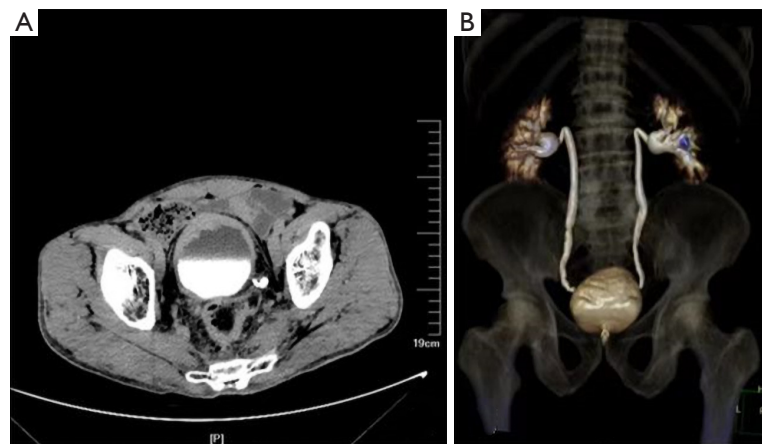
Imaging examination of the patient. (A) Computed tomography urography demonstrated irregular thickening of the urinary bladder wall and protrusion inside the bladder lumen, especially on the anterior wall of the bladder; (B) 3D reconstruction of the CT shows the lesion on the anterior wall of the bladder. CT, computed tomography.
